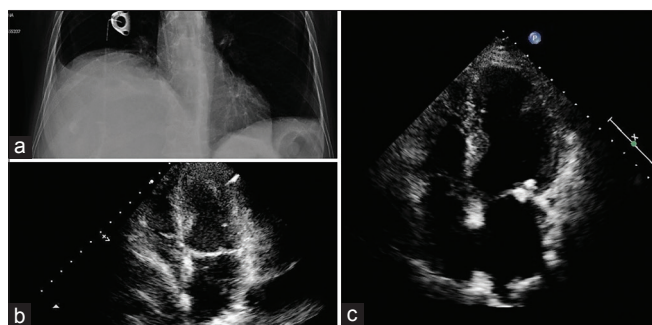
A chest radiography shows an elevation of the right hemidiaphragm (a), and a bedside transthoracic echocardiography demonstrated an ab-estrinsec compression of the right atrium (b). In the other patient, the transthoracic echocardiogram confirmed a note atrial septal aneurysm with patent foramen ovale (c)
